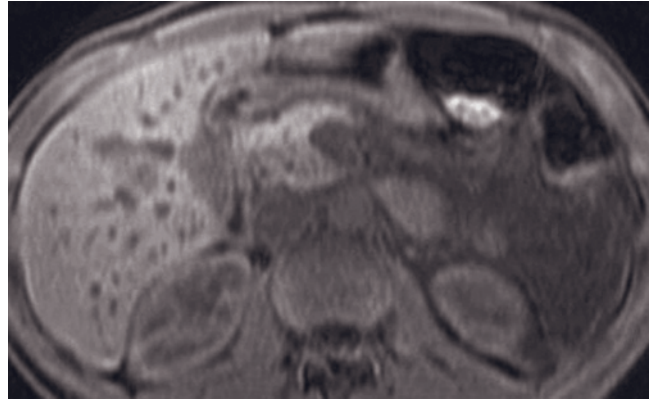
(Continued) Severe acute pancreatitis. T2-weighted fat-suppressed single-shot echo-train spin-echo (*g*), T1-weighted fat-suppressed SGE (*h*), and T1-weighted hepatic arterial dominant phase fat-suppressed 3D-GE (*i*, *j*) images at 3.0T demonstrate severe pancreatitis in another patient. The pancreas is diffusely enlarged and there is abundant free fluid (arrows, *g*) in the perihepatic space, bilateral anterior pararenal spaces, lesser sac, and left paracolic gutter. The pancreas shows diminished signal on T1-weighted SGE image (*h*). The enhancement of the pancreas is less than normal on postgadolinium images. The gallbladder wall (open arrow, *g*) is also thickened and edematous. The gallbladder wall, particularly the mucosa, (open arrow, *i*) shows intense enhancement on postgadolinium image (*i*). The stomach wall (curved arrow, *g*) is also thickened and edematous. There are regions of heterogeneous enhancement in the liver as well. Associated cholecystitis, gastritis, and inflammation in the liver are not uncommon in the presence of pancreatitis.
